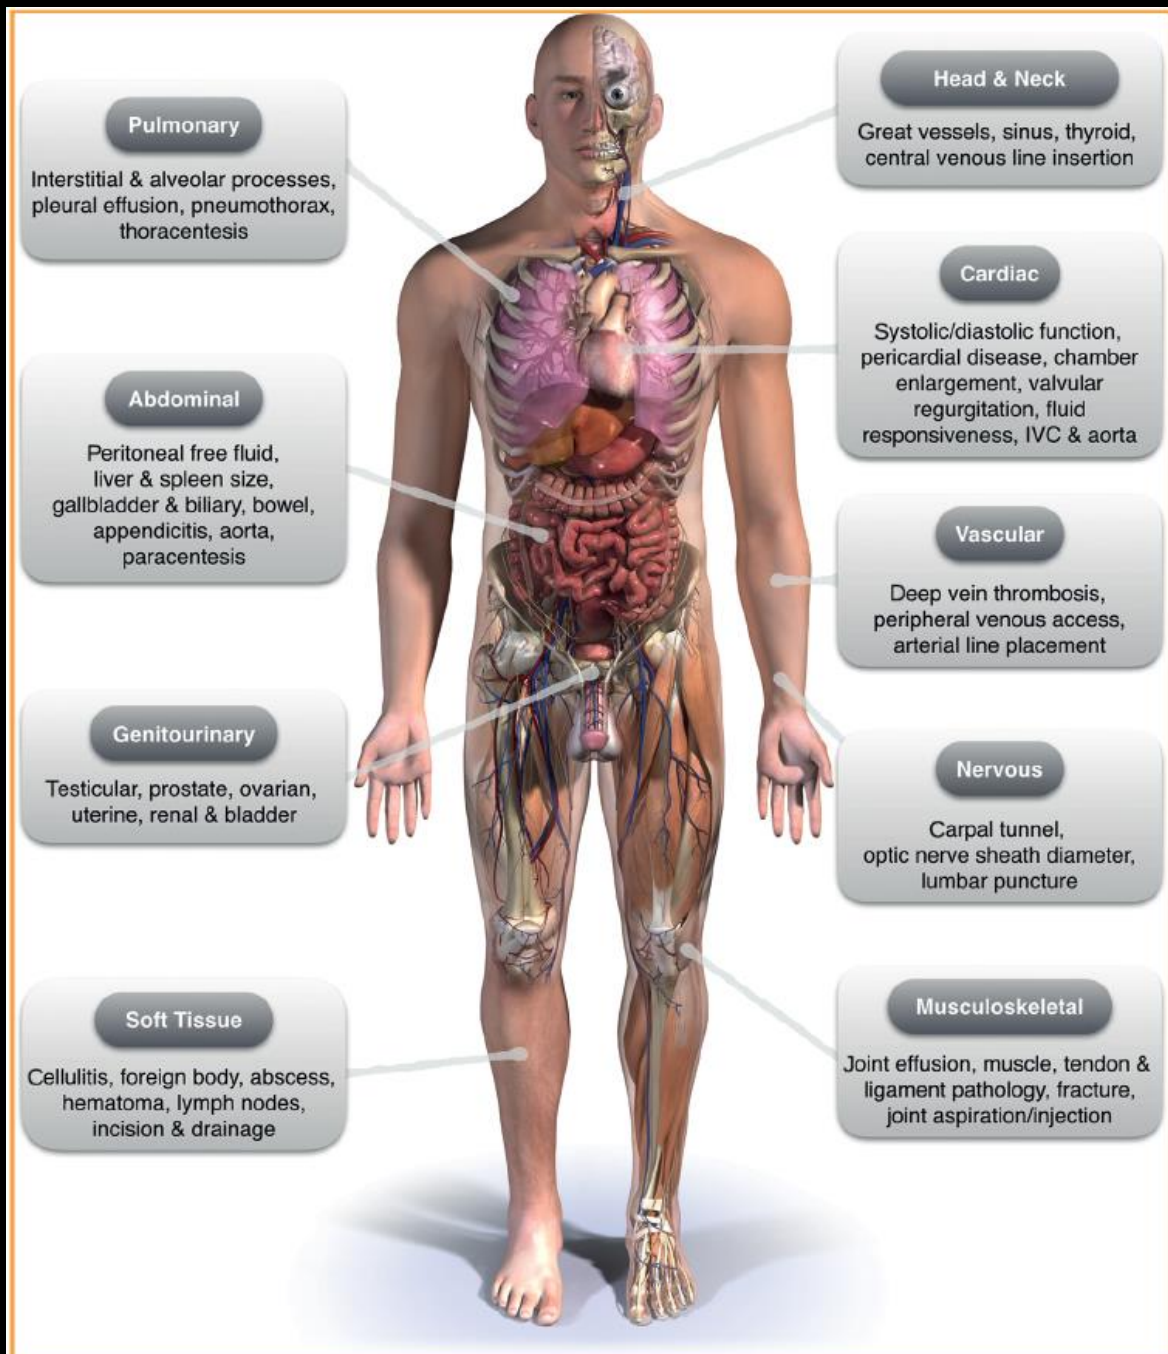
Internal medicine point-of-care ultrasonography applications. IVC = inferior vena cava
